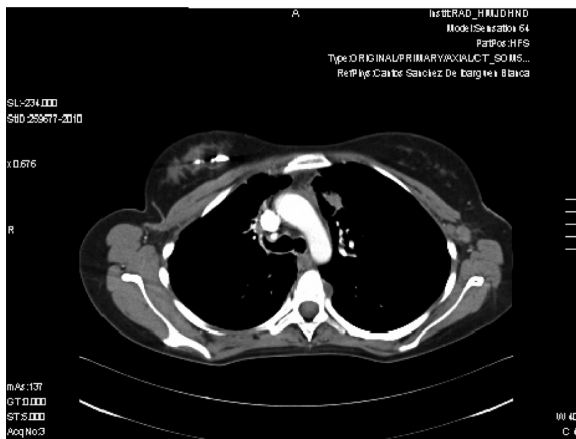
Computed tomograph scan of thorax-abdomen, April 6, 2011. Important decrease of prevascular mediastinal involvement.
